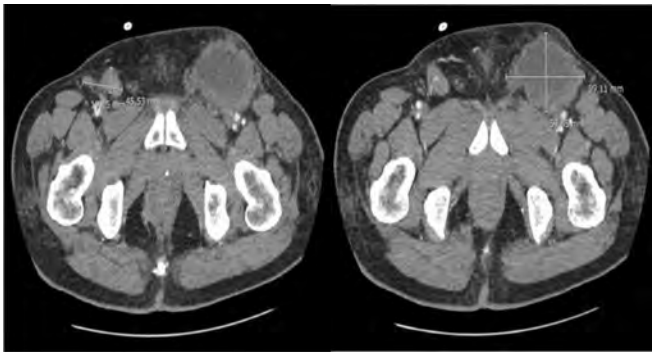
Contrast-enhanced abdominopelvic CT scan demonstrating bilateral inguinal lymphadenopathies measuring 9cm x 6cm on the left and 4cm x 2cm on the right with no radiologic evidence of distant metastasis.
